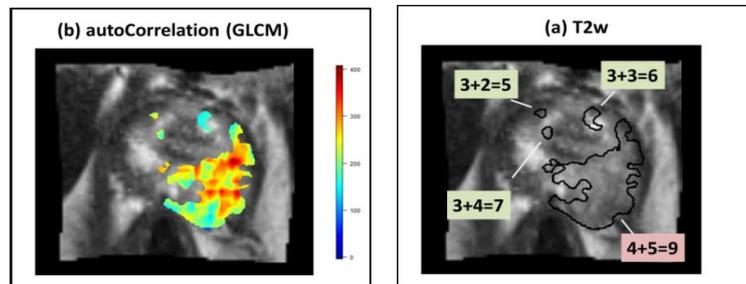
Predicting tumour grade using one of several methods described by Sun et al (*submitted*). GLCM: gray-level co-occurrence matrix. Left panel shows pathologist annotation overlaid on T2w MRI.
